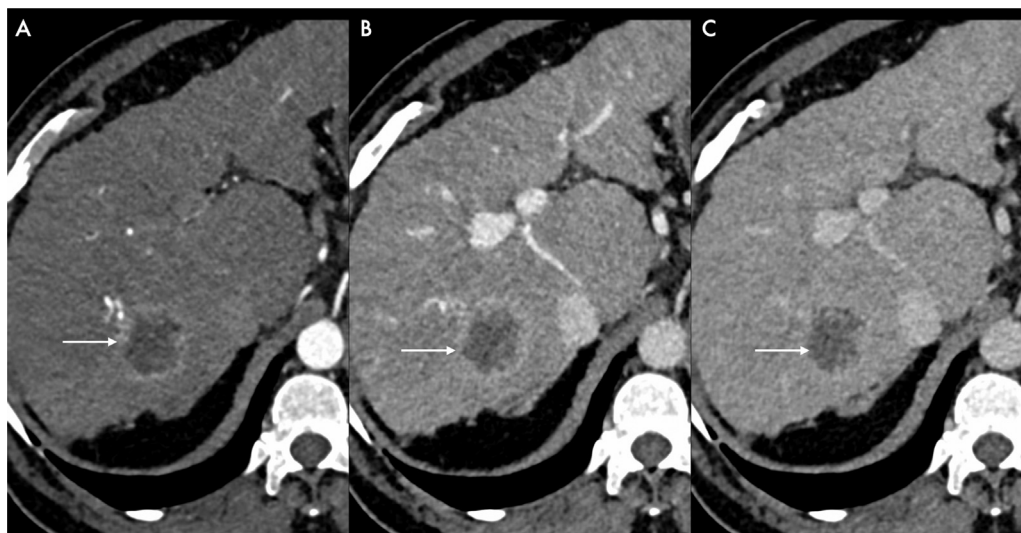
(A–C) LR-M observation: Contrast-enhanced computed tomography study shows a 32 mm observation (white arrow) in segment VII showing rim arterial phase hyperenhancement in late arterial phase (A) and portal venous phase (B) with peripheral washout in delayed phase (C).
